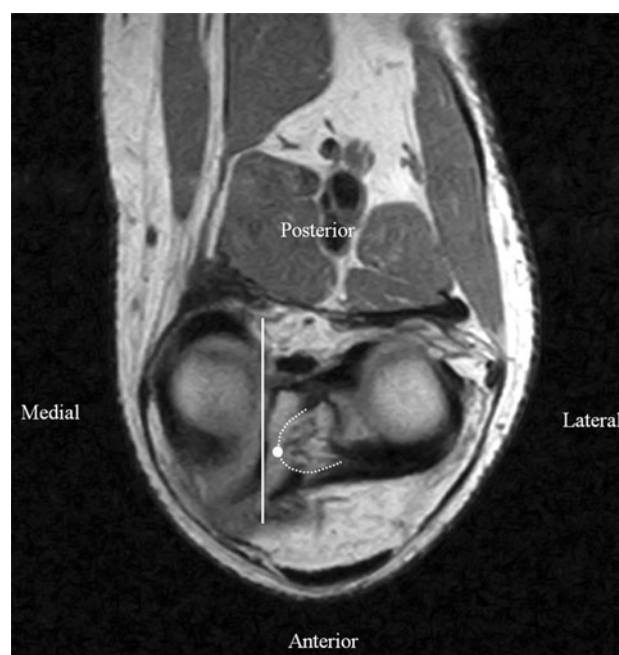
The medial border of the ACL at the tibial attachment (white circle) is seen on this MR image. We projected the medial wall of the intercondylar notch to the tibial plateau (white solid line), then extended the line to determine if it intersected the medial border of the ACL.
